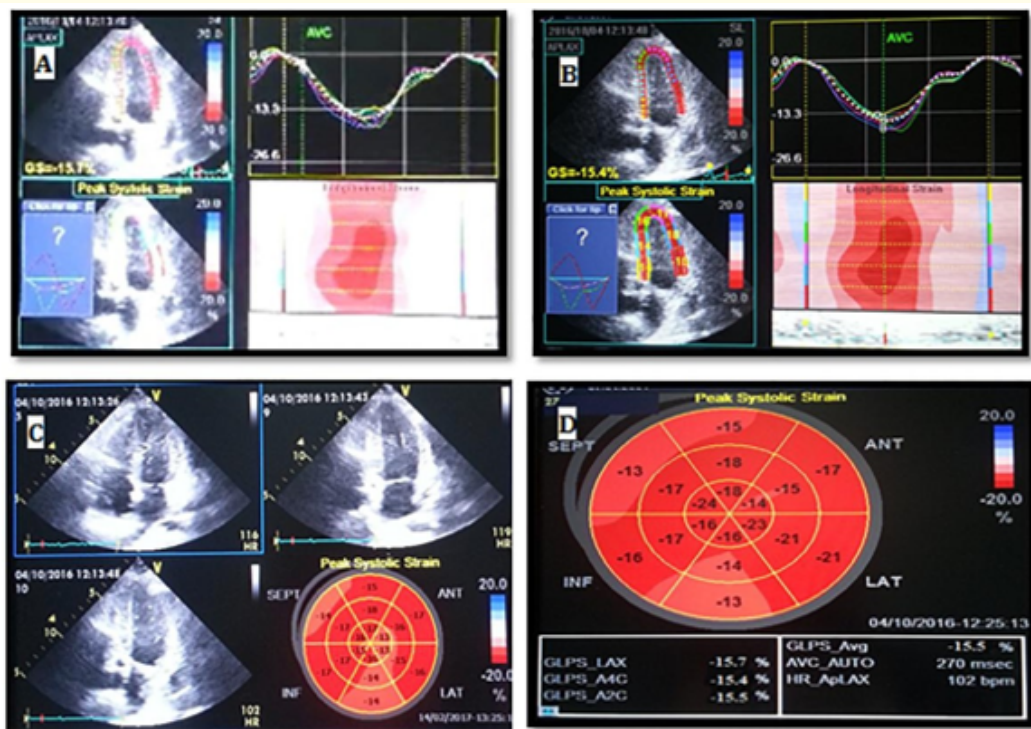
Echocardiographic assessment of 16 years old girl with Ewing sarcoma showing anthracyclines induced cardiotoxicity after the fifth cycle of anthracyclines (185 mg/m²). A: showed global longitudinal strain (GLS) in apical 3 chamber view measuring -15.7%, B: showing GLS in apical 4 chamber view measuring -15.4%, C: showing Bull's eye of GLS in apical 3, 4 and 2 chamber views measuring and D: showed average GLS of the 3 views which was -15.5%, this patient started cardiac supportive management.
